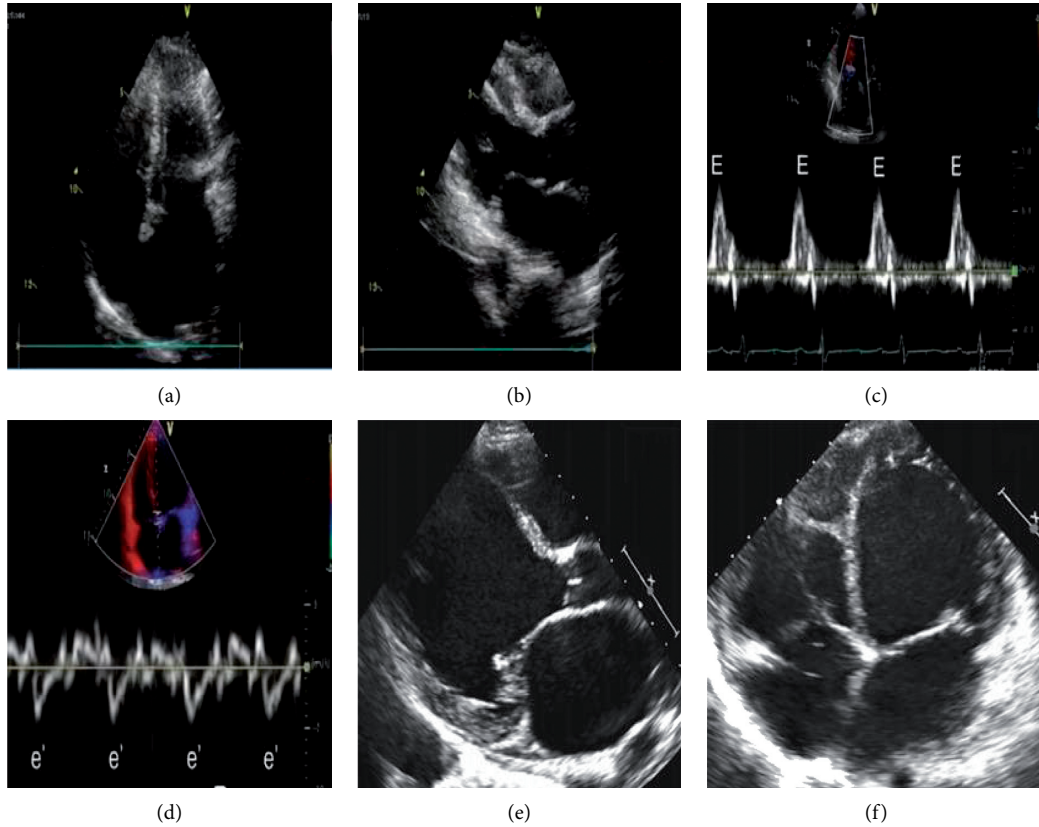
Partial ultrasound images of patients. Figures (a–d) are ultrasound images of patients with atrial fibrillation, E and e' peak refer to the flow velocity of the mitral valve in the early diastole, Figures (e, f) are ultrasound images of patients with atrial fibrillation and heart failure.
